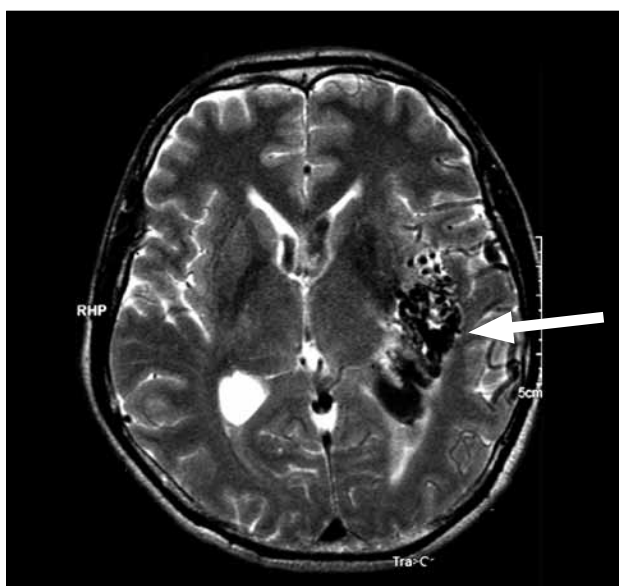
T2-weighted magnetic resonance image (spin-echo, TR 4700 ms, TE 100 ms) showing serpiginous tangle of vessels in the left basal ganglia (arrow) in keeping with a large arteriovenous malformation.
